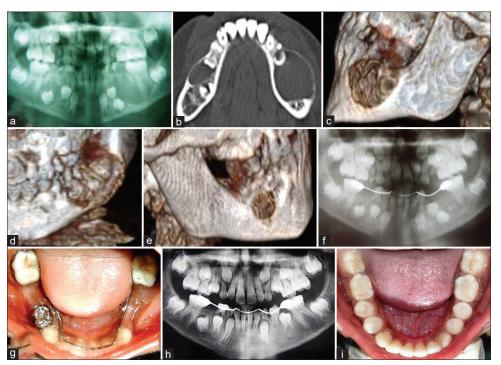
(a) Orthopantomograph; (b) computerized tomography scan (occlusal view); (c) computerized tomography scan (lower left side); (d) computerized tomography scan (lower left anterior view); (e) computerized tomography scan (lower right side); (f) orthopantomograph; (g) lower occlusal view; (h) orthopantomograph; (i) lower occlusal view
